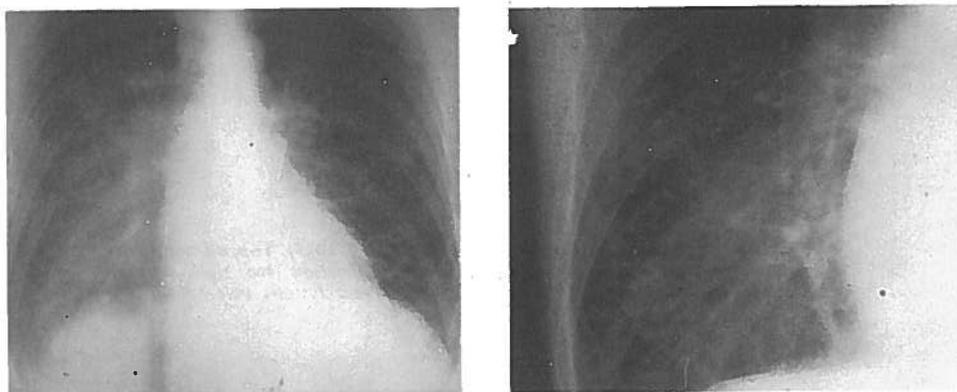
and 11 — X-Ray of a patient in the ICU, with myocardial infarction; Kerley B lines, areolar shadows. Hilar shadows and cisuritis lines seen.
